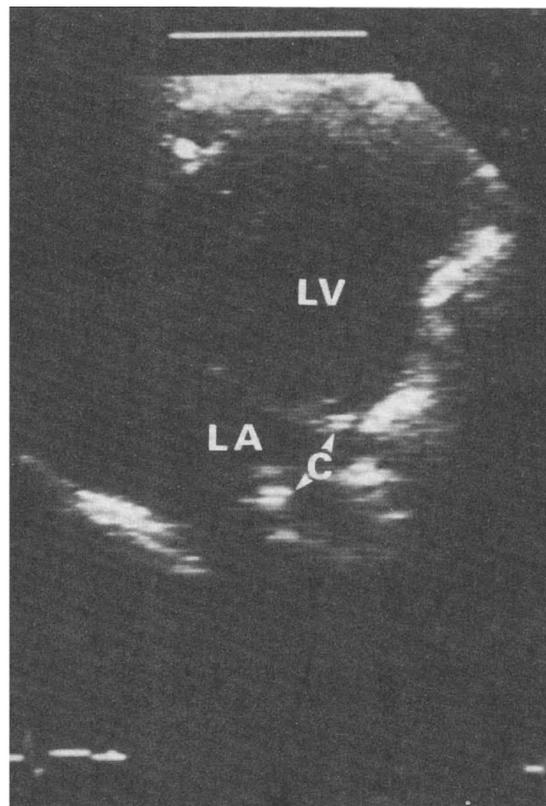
Two-dimensional echocardiogram in the apical four-chamber view showing the catheter (C) curved (arrows) behind the left atrium (la). ra = right atrium.
